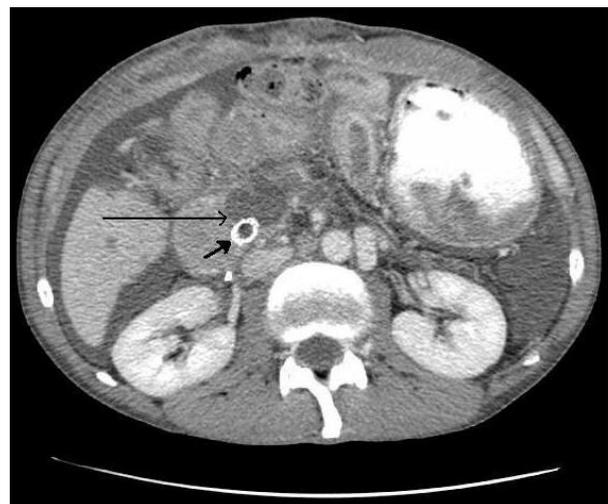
Postoperative CT scan showing a well defined homogenous low density area suggesting ablated tumour (long arrow). Note metal stent in situ (short arrow) and presence of ascites.
